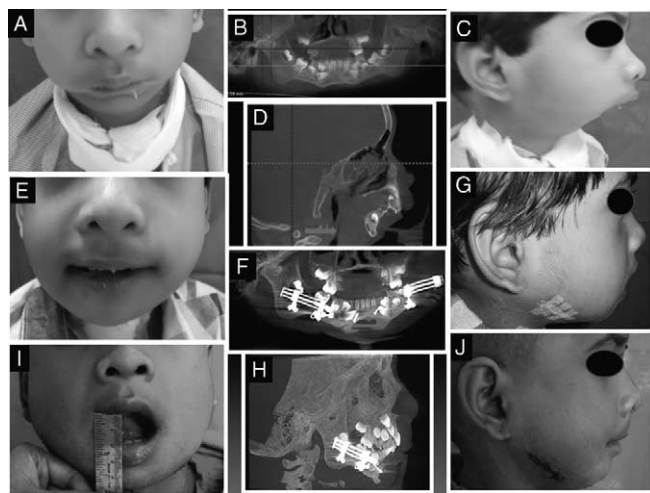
A to C, Predistraction clinical and radiologic images showing recessed chin and bilateral TMJ ankylosis. D, Radiographic airway assessment showing narrowing of airway; E to G, Postdistraction clinical and radiologic images with lag screw (arrow) in situ used to fix genioplasty. H, Postdistraction widening of airway with distractors in situ (arrow). I to J, Postankylosis release.
